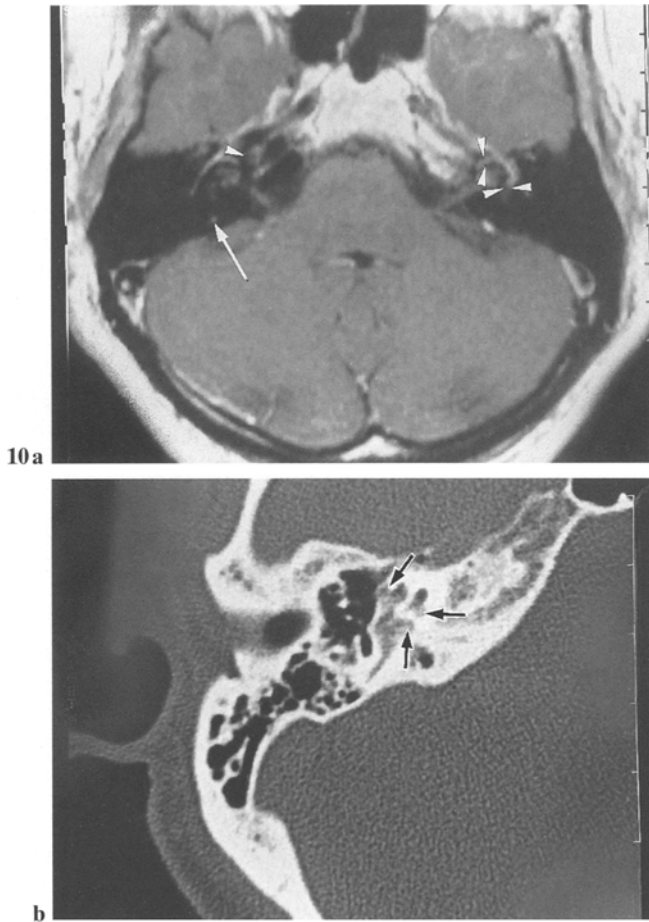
a, b. Patient referred before cochlear implant surgery. a Enhanced T1WI MR shows a bilateral weak enhancement of the otic wall (*arrowhead*) medial to the facial nerve. Enhancement of the right endolymphatic sac (*arrow*) and of the fundus of the IAC (*curved arrow*) is depicted. b CT scan depicts pericochlear hypodense areas (*arrows*): active cochlear otospongiosis
